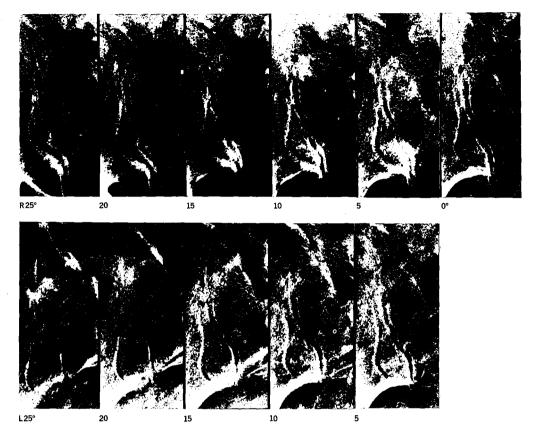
Right SI joint; plain radiography. X-rays at 5° interval from 25° right to 25° left direction to show the effect of oblique projection. With every step other portions of the joint come into view. The first radiograph at 25° shows the superimposed projection of the ventral and dorsal portion; the middle portion is seen continuous with the dorsal portion 0°.
